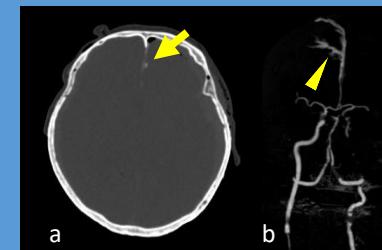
Selective cerebral computed tomography angiography image. a) Extravasation at the longitudinal cerebral fissure between the frontal lobes (arrow). b) Reconstructed angiography image showing an extravasation from the small aneurysm of the left distal anterior cerebral artery (arrow head).
